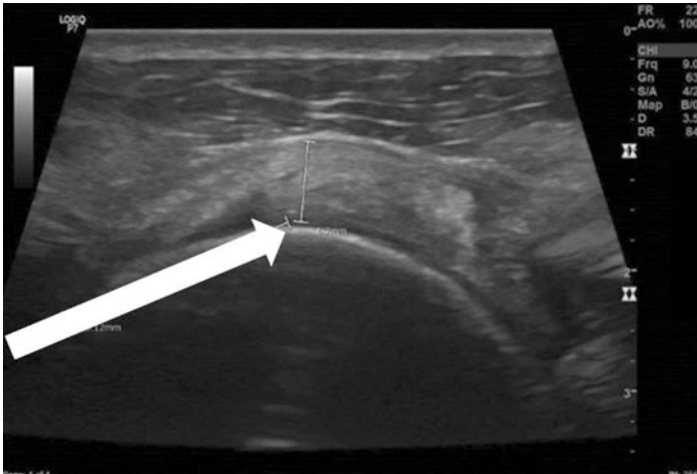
Ultrasound imaging demonstrating diffuse supraspinatus tendon thickening and hypoechoogenicity (white arrow), consistent with supraspinatus tendinopathy. (Used with permission from: Niazi et al. [33])
